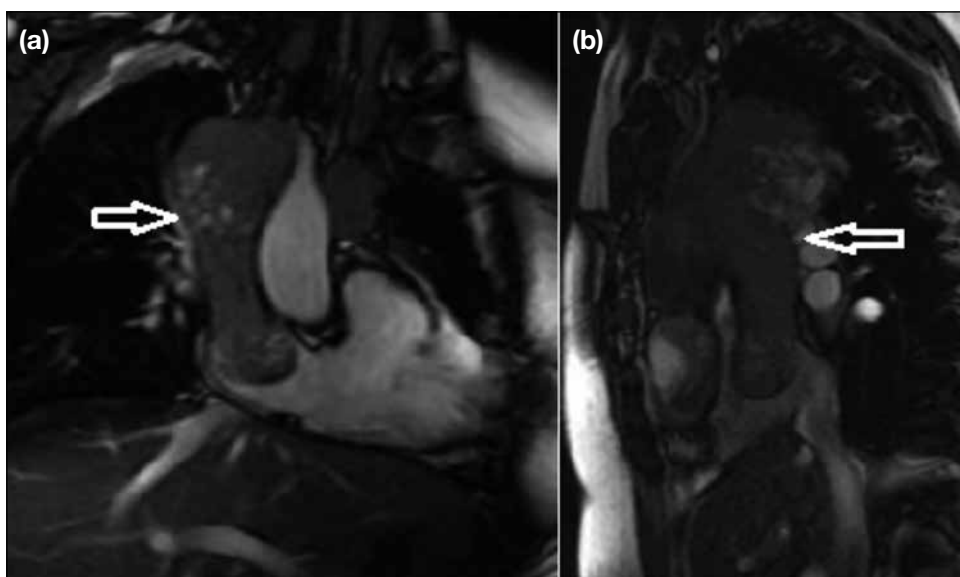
Cardiac magnetic resonance images of a 74-year-old male patient diagnosed with invasive thymoma. Coronal (a) and sagittal (b) images showing the tumour (arrows) reaching the right atrium via the superior vena cava.
